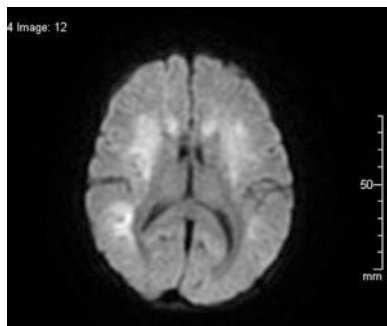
MRI brain: T2WI sequence axial image showing multiple patchy hyperintensities in bilateral parieto-temporal-occipital lobes involving cortical and subcortical white matter and bilateral globus pallidus
